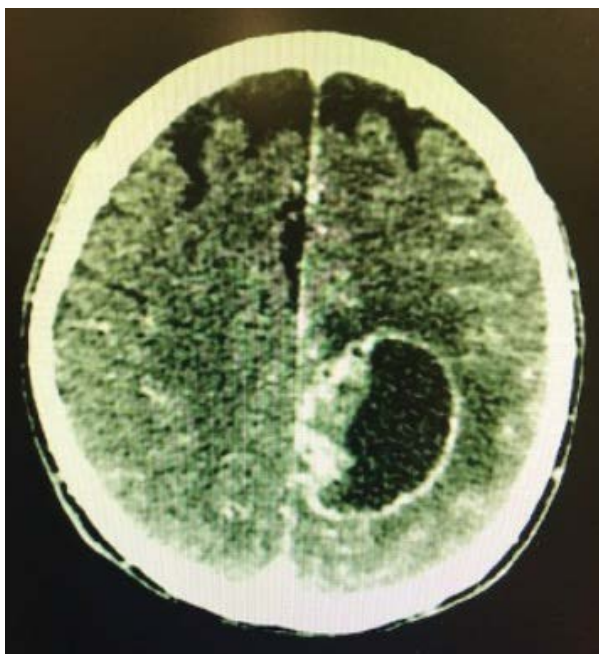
Left occipital mass in CT.
